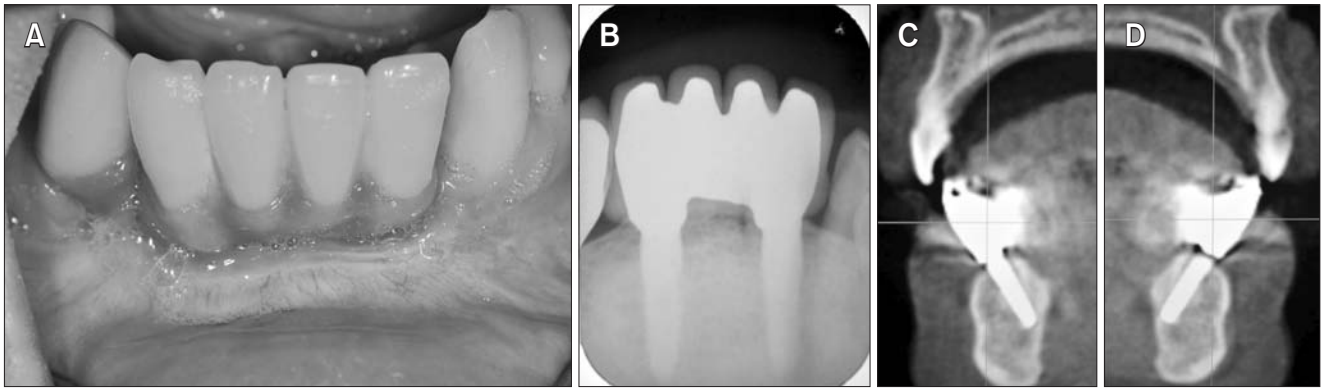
Pictures at 6.5 years after interpositional bone graft. (A) A clinical photograph with stable vestibule. (B) Periapical radiograph with stable crestal bone. (C, D) Computed tomography scans show the favorable quality of alveolar bone.
